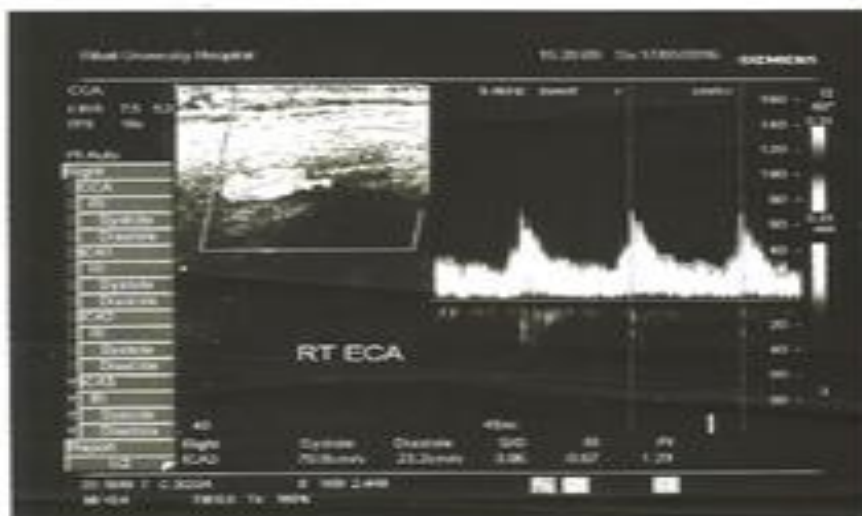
Rt ECA-male- 49 years diabetic patient with normal Doppler parameters.
